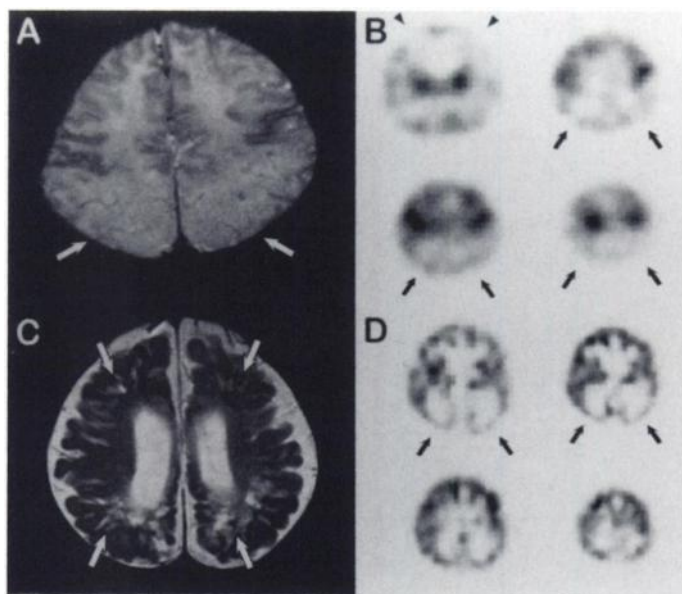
Patient 1. (A) Initial T2-weighted axial MR image reveals hyperintense region over bilateral parieto-occipital lobes (arrows). (B) Transverse ^{99m}Tc -HMPAO SPECT image demonstrates relative hypoperfusion in bilateral frontal areas (arrowheads) and pronounced hypoperfusion in bilateral occipital and posterior parietal areas (arrows). (C) Follow-up T2-weighted MR image shows encephalomalacia (arrows) with cerebral atrophy. (D) Technetium-99m-HMPAO SPECT image demonstrates persistent hypoperfusion in bilateral occipital and posterior parietal areas and cerebral atrophy (arrows).
